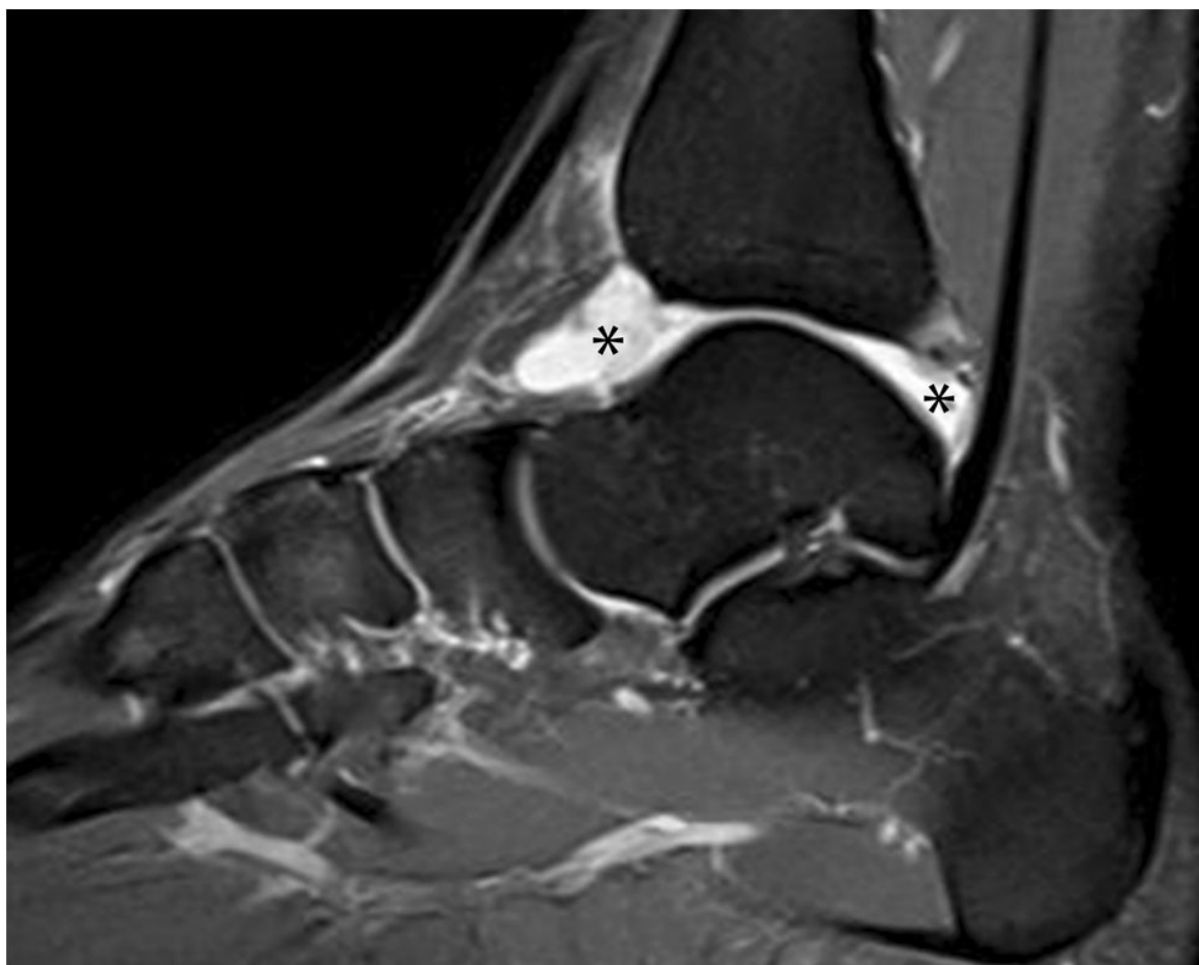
Sagittal proton density-weighted MRI shows Grade 2 effusion in the tibiotalar joint (*)
